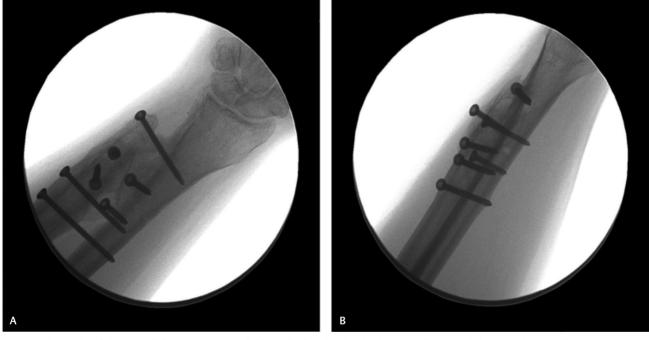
Radiographs of the wrist ([A] posteroanterior, [B] lateral) after distal radioulnar joint fusion with iliac crest bone graft.
